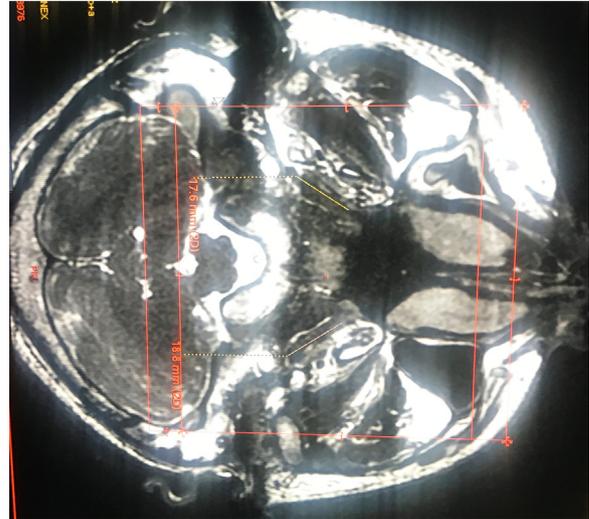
Magnetic resonance image of the attachment of the tensor veli palatini.
